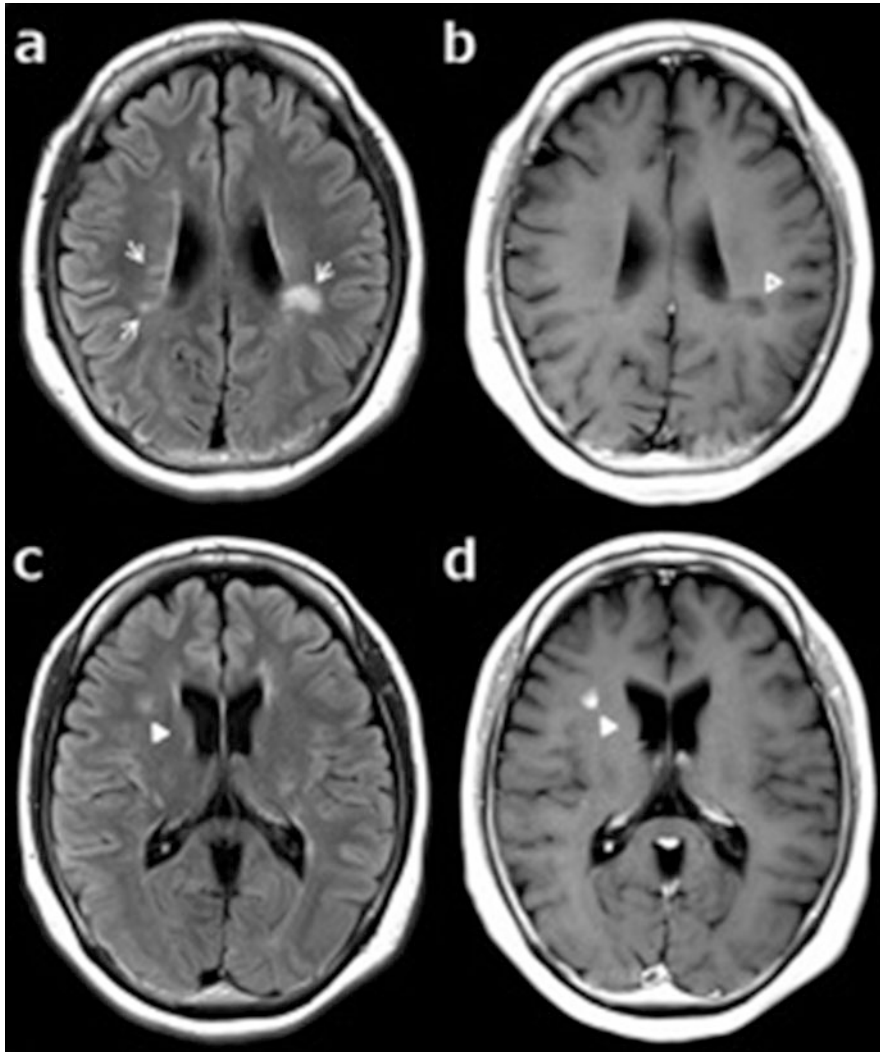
MRI profile of MS plaque. (a) Arrows show ovoid lesions in a FLAIR image, (b) one of which has formed a T1 black hole (open arrowhead) shown by T1-weighted imaging. (c) High-signal lesion (arrowhead) in a FLAIR image showing (d) gadolinium enhancement
